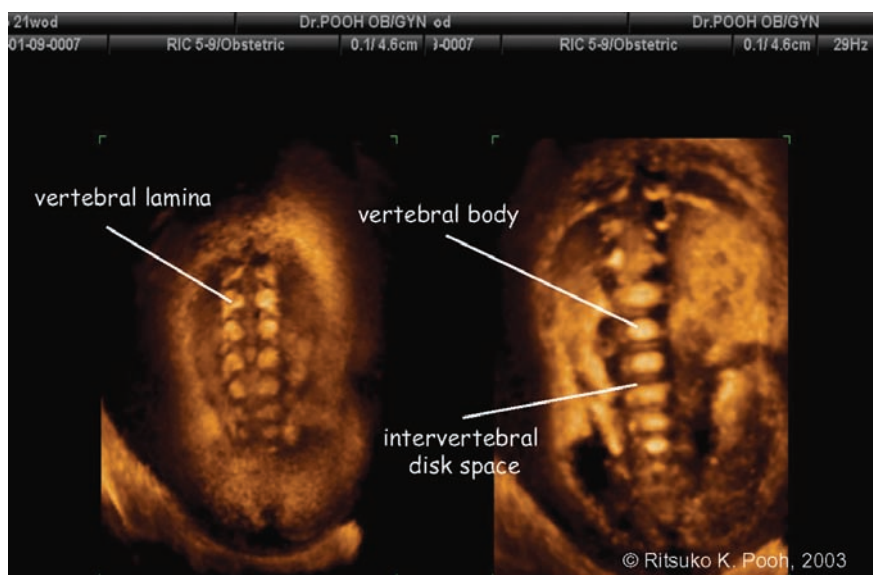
Fetal vertebral structure by 3D ultrasound at 21 weeks of gestation.
